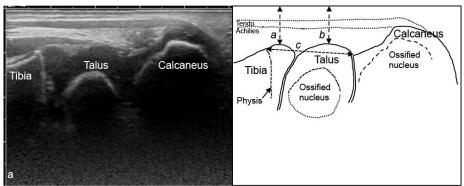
Posterior ultrasonography scan of the left foot in a neutral position in a 1.5year-old boy with bilateral clubfeet. (a) Skin – tibia distance. (b) Skin – talus distance. (c) Tibial physis – talo-calcaneal joint distance (Tib.phys.-TCJ).
